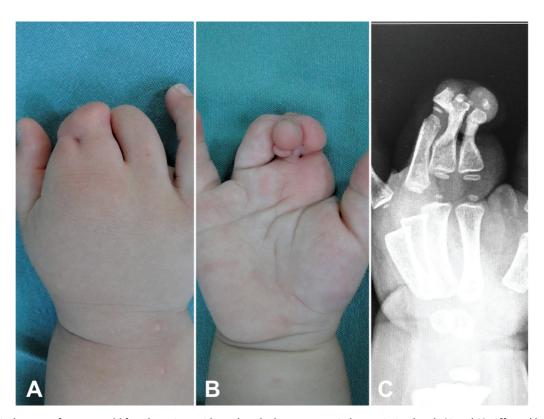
Clinical aspect of two-year-old female patient with syndactyly due to congenital constriction bands (A and B). Affected hand radiograph (C).
